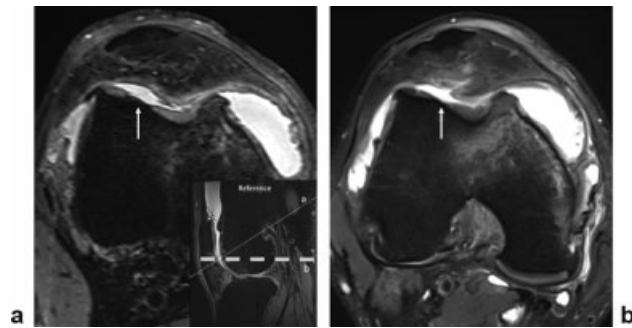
(a) A moderate-sized full-thickness chondral fissure/defect in the lateral trochlea (arrow) is well visualized and characterized on a thin three-dimensional (3D) fast spin-echo (FSE) axial oblique multiplanar reconstruction (MPR) due to optimal orientation of the imaging plane perpendicular to the curved articular surface of the trochlea at the site of the defect. (b) The same lesion (arrow) is suboptimally characterized on the two-dimensional (2D) T2-weighted FSE standard axial sequence due to partial volume averaging with adjacent cartilage as a result of thicker slices and oblique orientation of the imaging plane through the defect. A sagittal reference image (a, lower right corner) demonstrates the thinner 3D MPR plane (thin line) and the thicker standard axial 2D plane (thick dashed line).
